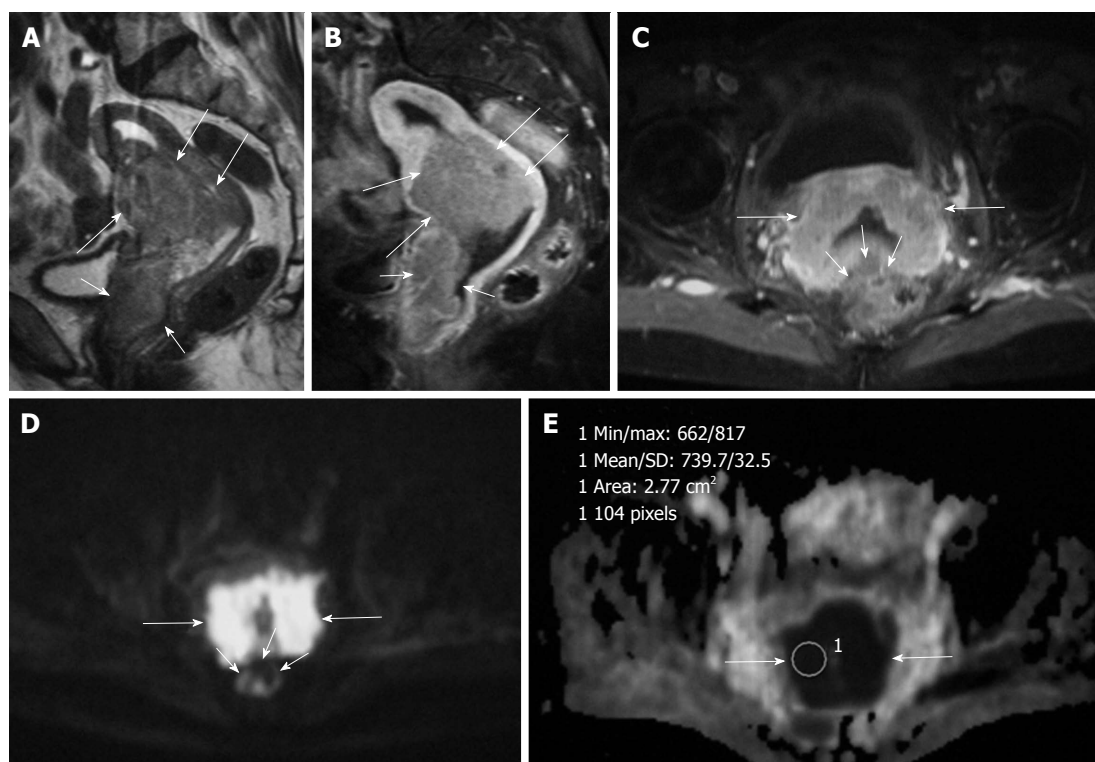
Forty-three years old woman with stage III squamous cell carcinoma of the uterine cervix invading vagina. A: Sagittal T2-weighted image of the uterus shows cervical cancer (long arrows) extending both to the corpus uteri and vagina (short arrows); B: Sagittal contrast-enhanced T1-weighted image with fat suppression shows enhancing cervical cancer (arrows). The tumor invades anterior vaginal wall (short arrows); C: Axial contrast-enhanced T1-weighted image with fat suppression shows enhancing cervical cancer (long arrows). There is suspicious invasion of the mass to the rectum (short arrows); D: Diffusion-weighted imaging with $b = 1000 \text{ s/mm}^2$ clearly shows a well-defined hyperintensity mass in the cervical area with no invasion to rectum (short arrows); E: On the apparent diffusion coefficient (ADC) map the tumor is hypointense (arrows). The ADC value within the mass is $0.73 \times 10^{-3} \text{ mm}^2/\text{s}$.
